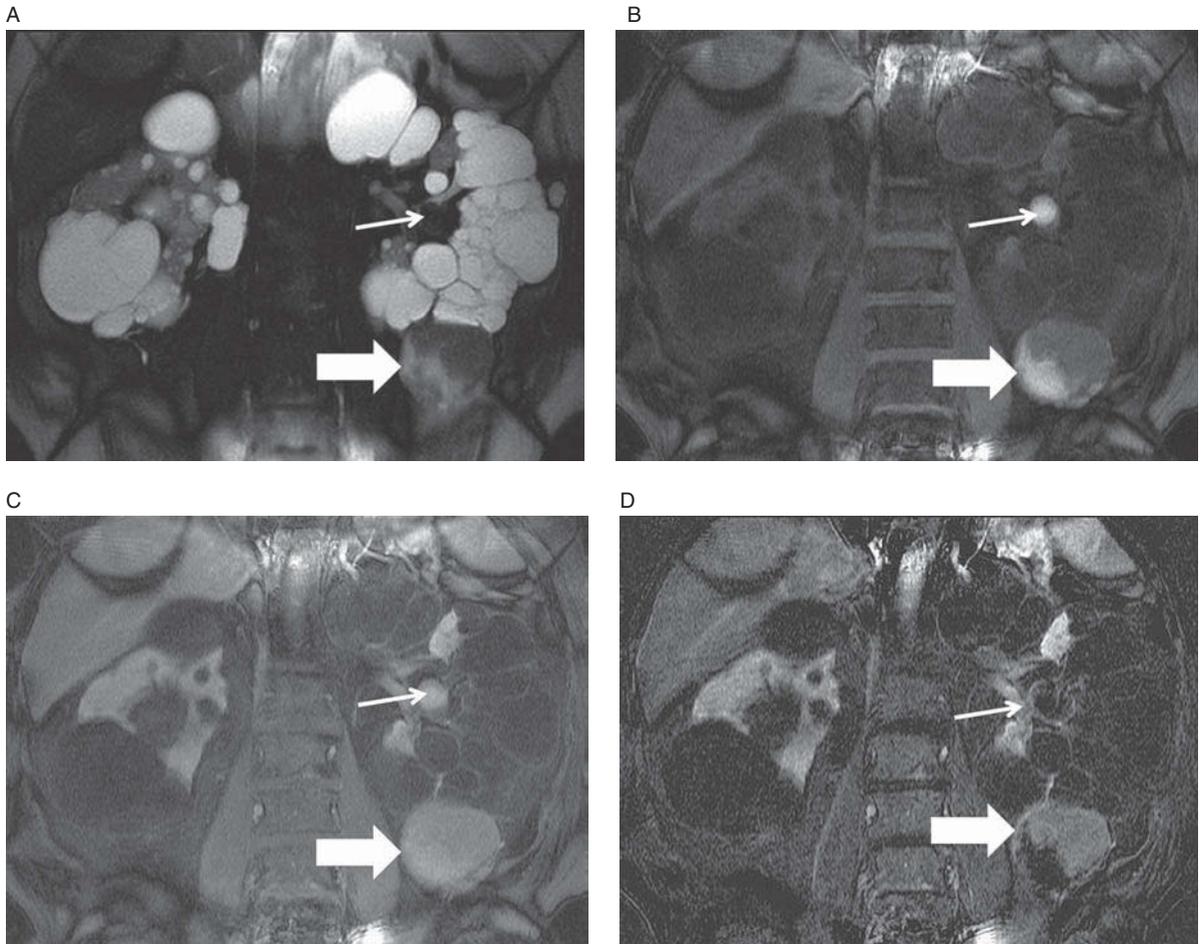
Polycystic kidney disease (PCKD) with complex cyst and renal cell carcinoma. This is quite simply the greatest example of renal subtraction imaging ever – take your time with it. Coronal T2-weighted image (A) demonstrates enlarged kidneys with innumerable renal cysts compatible with PCKD. There are innumerable simple renal cysts which are bright on T2-weighted image (A), and dark on T1-weighted, fat-saturated pre- and post-contrast images (B, C). Note the T2-dark lesion in the left interpolar region (line arrow) and the heterogeneous lesion in the left lower pole (block arrow). Axial T1-weighted, fat-saturated pre-contrast image (B) shows T1-bright signal within the interpolar lesion and heterogeneous signal within the lower pole lesion. Quite frankly, it’s tough to figure out what’s happening in post-contrast image (C). Is there any true enhancement . . . if so, where? Subtracted image (D) saves the day. The interpolar lesion loses all signal = no enhancement = benign, complex cyst. The lower pole lesion demonstrates mass-like enhancement in its superior portion = renal cell carcinoma.
